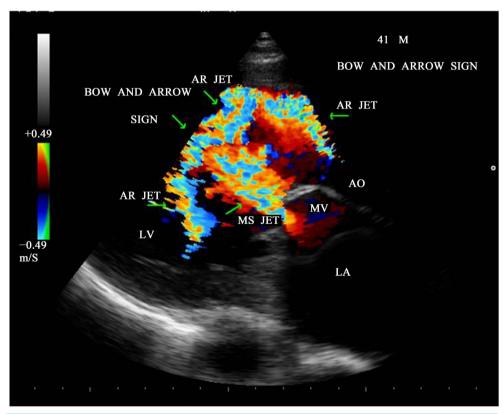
CW doppler showing the MS jet collide with AR jet and a "bow and arrow" appearance in parasternal long axis view.
